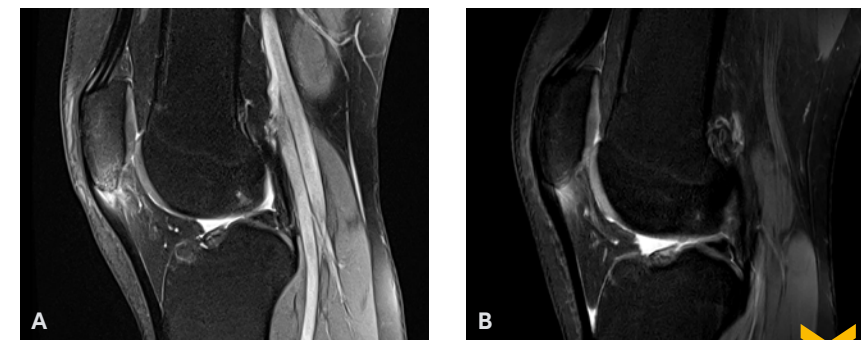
MRI scans acute (A) and after ten weeks (B)
